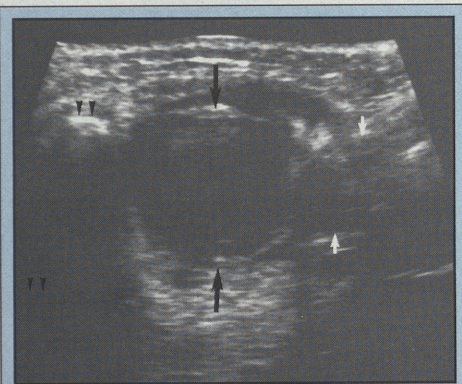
Longitudinal sonogram of the submandibular area showing a malignant node (black arrows) adjacent to the mandible (arrowheads). White arrows identify the visualised portion of the submandibular gland.
